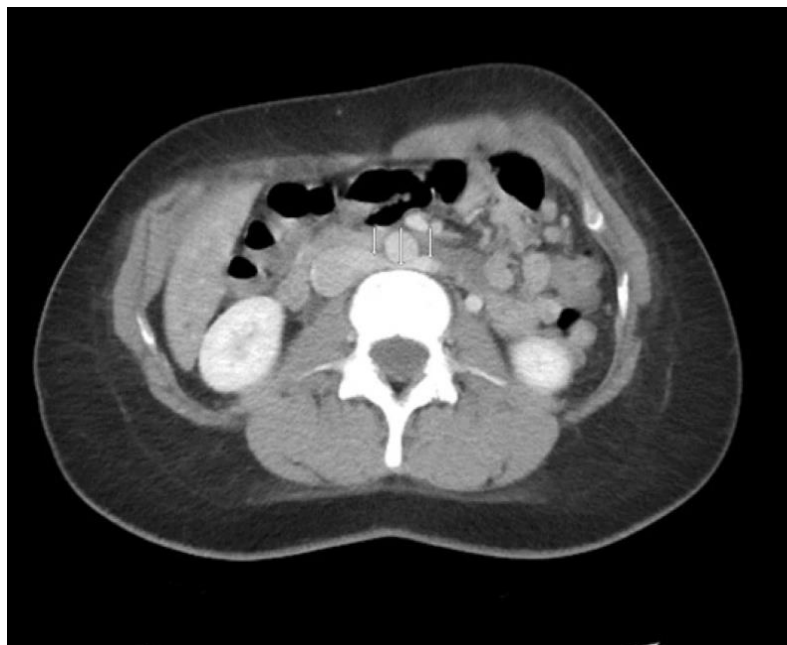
Computed tomography scan demonstrating retroaortic left renal vein (LRV) position.
